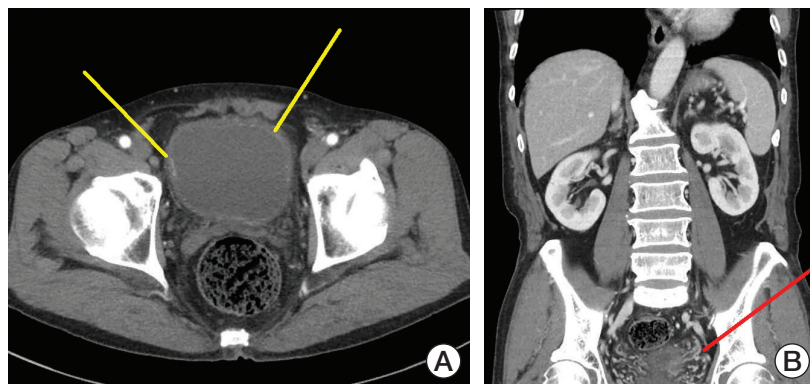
Computed tomography scan shows multiple enhancing lesion at bladder mucosa (yellow lines) (A) and segmental enhancement of the left distal ureter (red line) (B).
